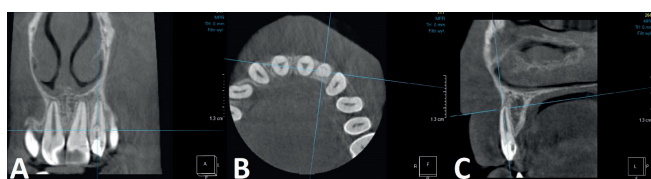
Cone beam computed tomography: A. sagittal section view; B. axial view; C. cross-sectional view
